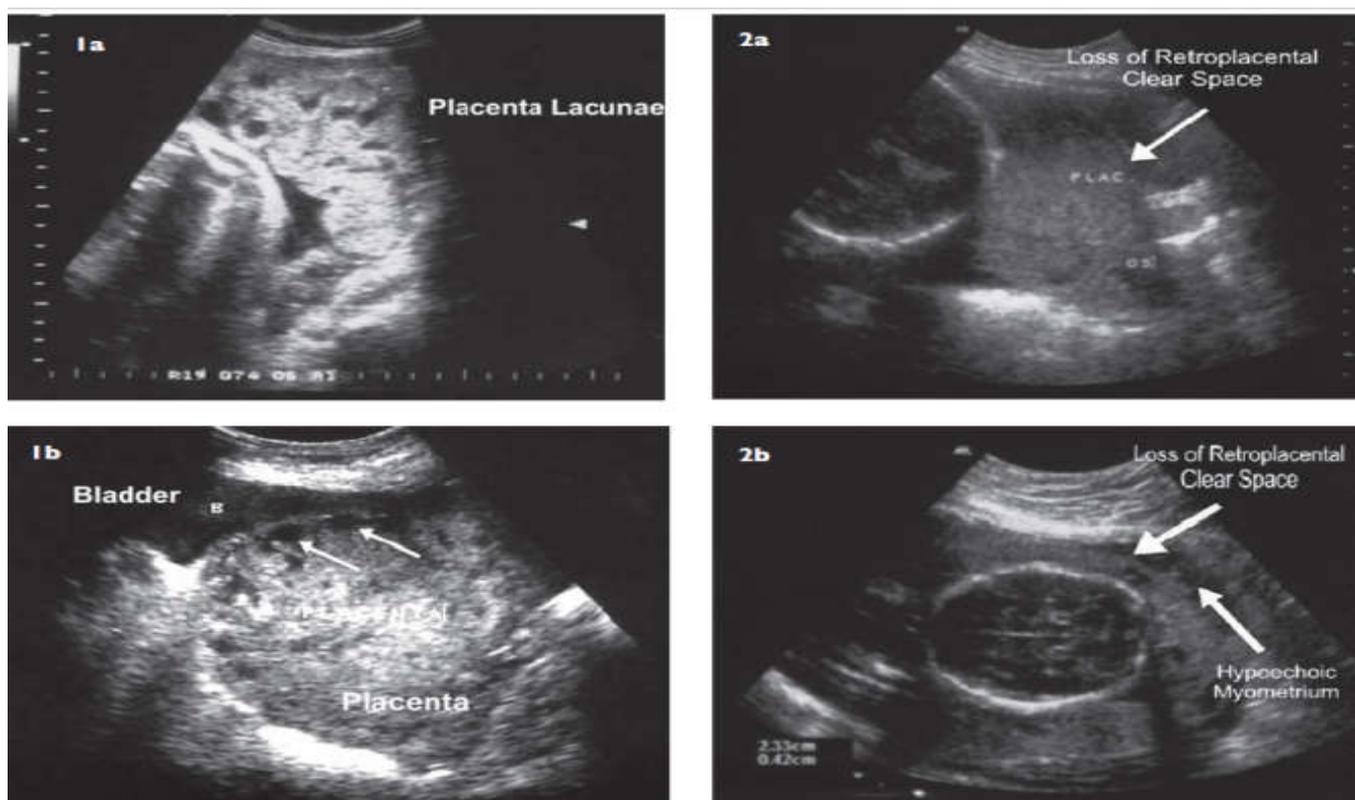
Shows most of grey scale ultrasound scan findings in placenta accrete
